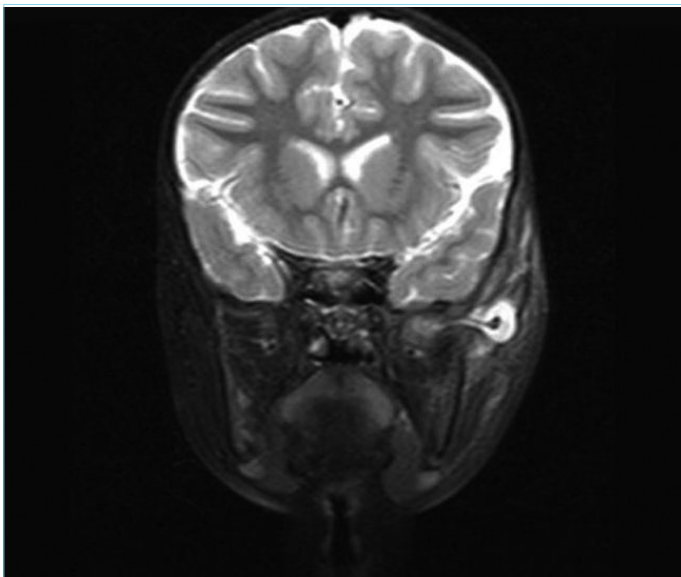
Picture showing a left-sided zygomatic abscess in the coronal section of MRI
